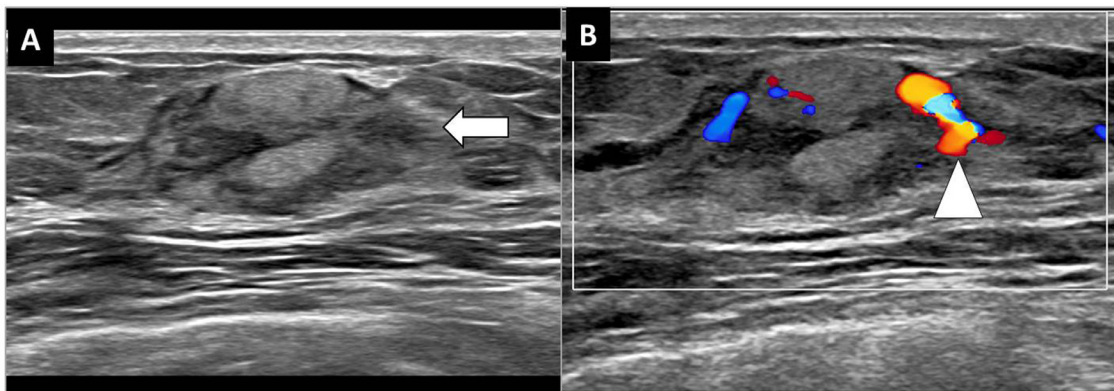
(A) Greyscale ultrasound image of the right breast shows an oval, heterogeneous solid mass, with mostly well-defined and peripherally indistinct margins (arrow) in the right breast at 2 o'clock axis, 5 cm from the nipple. (B) Color Doppler shows mass has internal vascularity (arrowhead).
